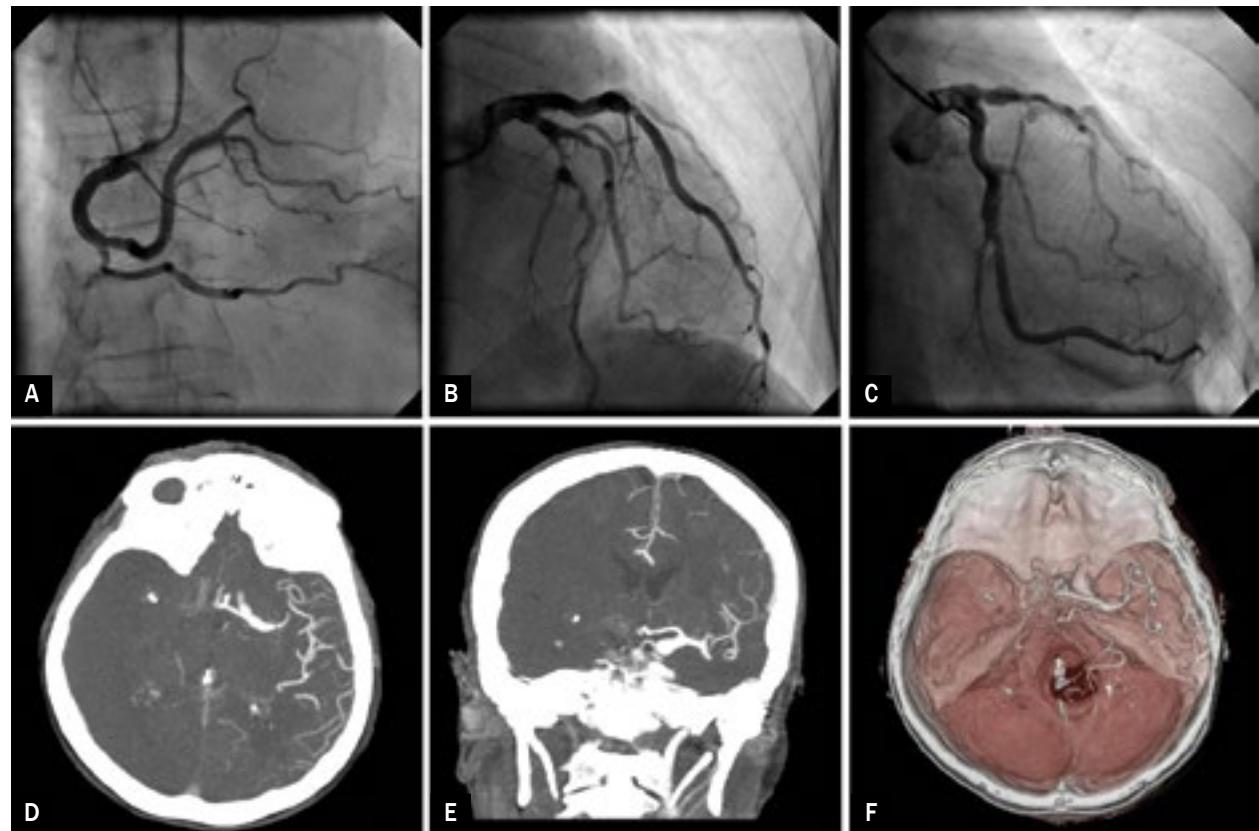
Right coronary artery; B, C. Chronic total occlusion of left anterior descending coronary artery; D.-F. Right intracerebral artery occlusion – transverse, frontal views, three-dimensional (3-D) angiography computed tomography (angio-CT) reconstruction
